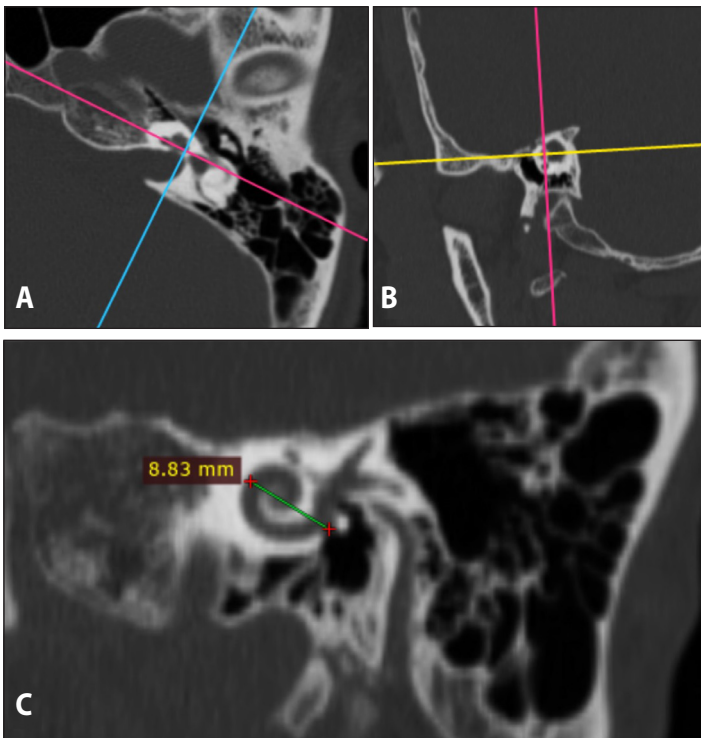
Temporal bone CT bone window images of the left ear showing the basal turn of the cochlea: A. plain axial; B. plain sagittal cuts; and C. Coronal oblique image obtained from multiplanar reconstruction of the same axial and sagittal cuts showing measurement for 'A' value
